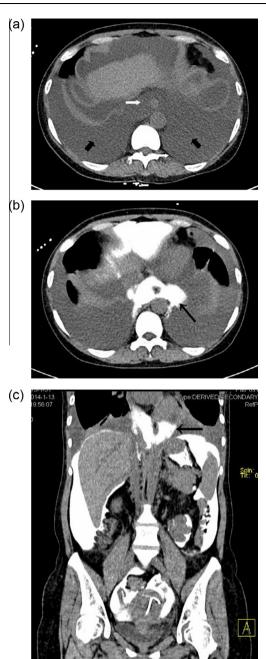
Non-enhanced CT (a) shows that a moderate amount of watery density shadow was seen in the posterior mediastinum (white arrow) and bilateral thoracic cavity (black arrow), axial (b) and coronal (c) CT peritoneography shows the posterior mediastinum surrounded by peritoneal dialysis solution containing contrast media (black arrow).
